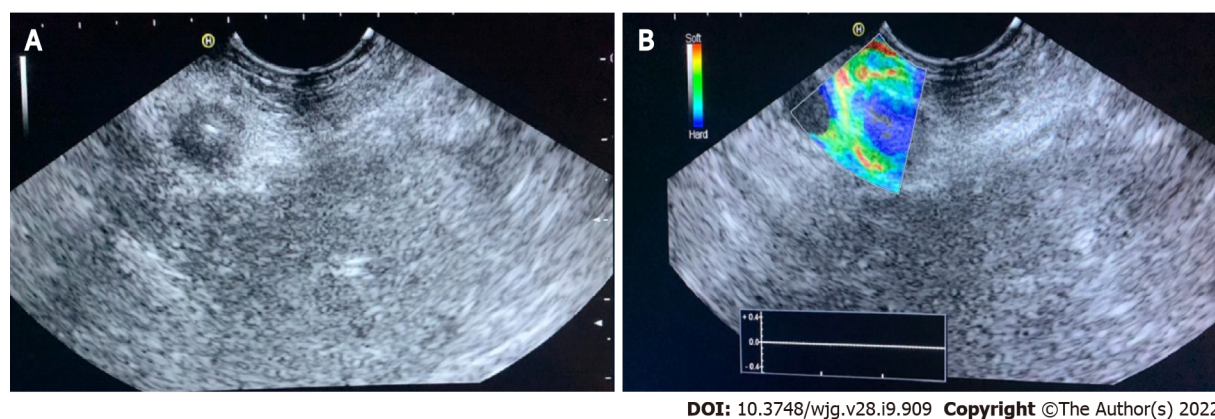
Qualitative endoscopic ultrasound elastography of a neuroendocrine malignant tumor of the pancreatic tail. A: Endoscopic ultrasound B-mode; B: Elastographic image.
